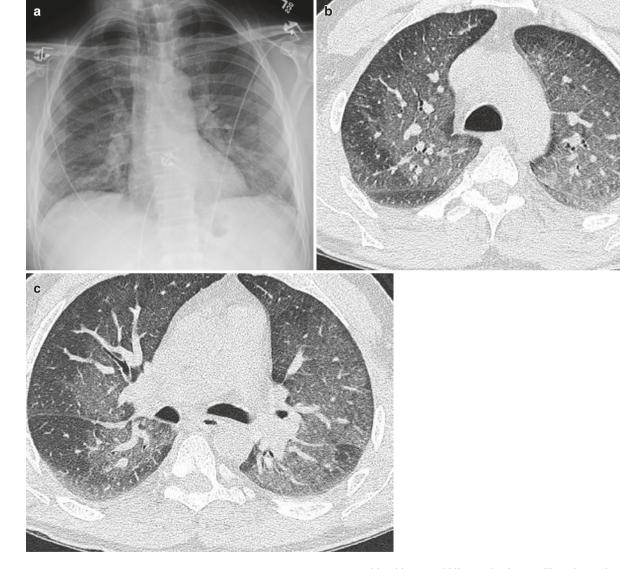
PCJ infection in an immunocompromised male patient. (a) Frontal chest radiograph shows subtle diffuse haziness. (b, c) Axial CT images in lung window show extensive ground-glass pattern densities
